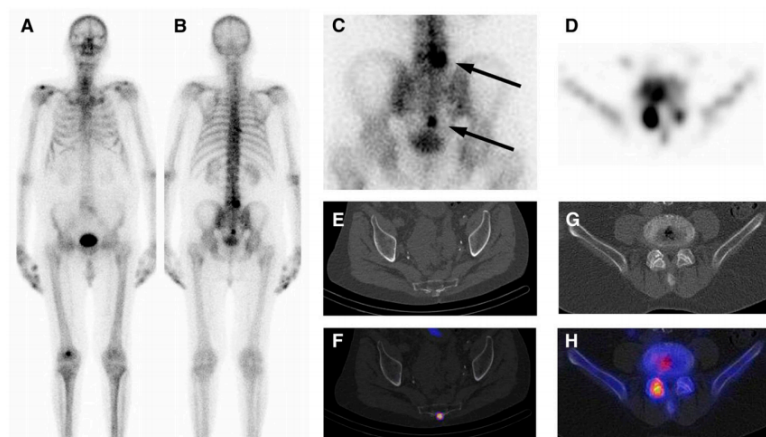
A and B: Planar scintigrams from planar bone scintigraphy. C: Detailed view of pelvis with 2 hot spots (arrows). D: SPECT image, transverse section of upper lesion in lumbar vertebra 5. E: Small osteolytic lesion with intense tracer uptake indicating bone metastases in lower pelvis. E,F,G and H: SPECT/CT, fused image [13].
